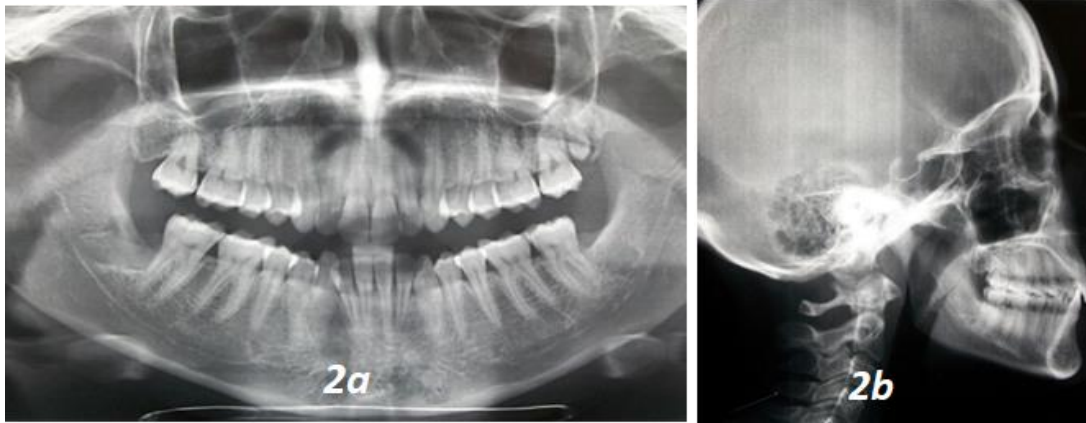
(a-b): Pre-treatment radiographs
